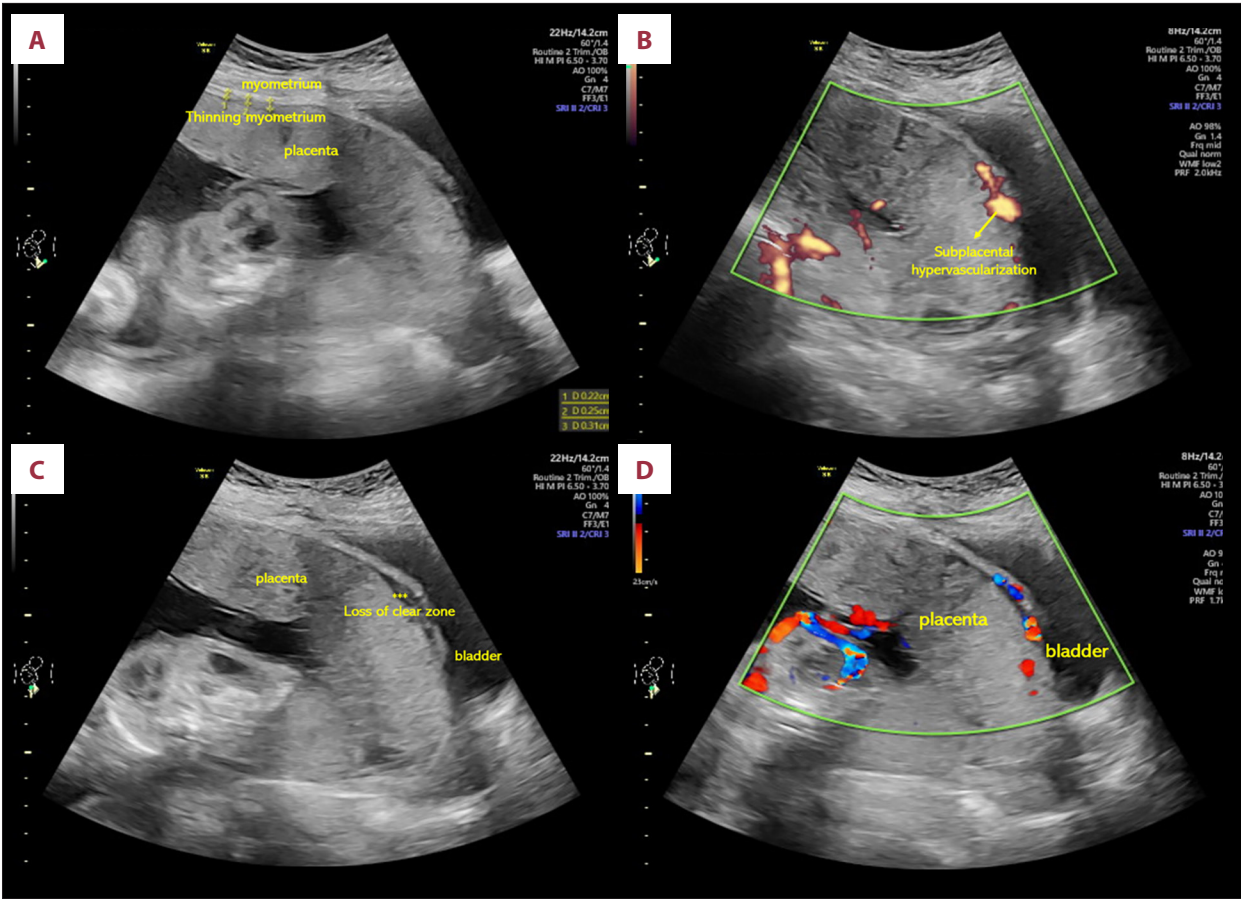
Ultrasound scan result showing features of placenta accreta spectrum: (A) thinning of the myometrium; (B) suplacenta hypervascularization; (C) loss of clear zone; and (D) subplacental hypervascularization on Doppler view.
